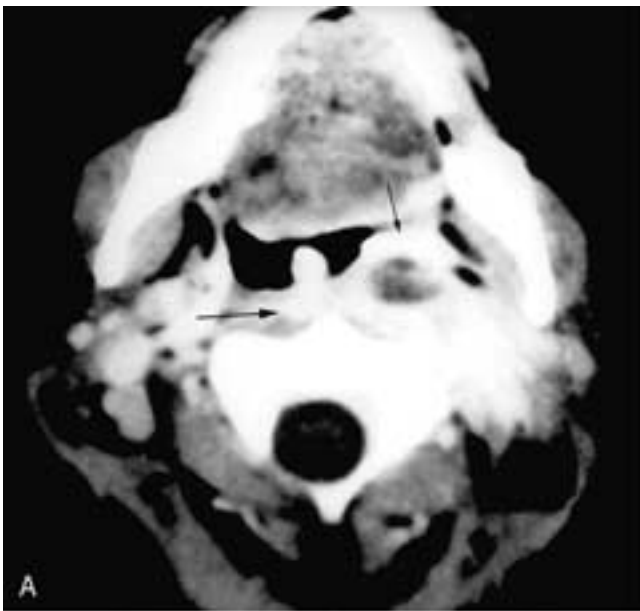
Axial contrast-enhanced CT scan (A) shows a necrotic left retropharyngeal node (*small arrow*) with a thick, enhancing rim. The enhancement extends to fill almost the entire retropharyngeal space (*large arrow*) and extends beyond the space into the left posterior neck. This was an abscessed node with a retropharyngeal abscess. Axial T1-weighted MR images (B) of another patient. There is a localized area of high signal intensity that is an abscessed left retropharyngeal node (*arrow*). Note that the remainder of the retropharyngeal space is not involved. In a third patient (C), there is a left abscessed retropharyngeal node; however, the remainder of the retropharyngeal space is also affected by an abscess. It is this latter extension that differentiates a retropharyngeal abscess with an abscessed node (C) from an abscessed retropharyngeal node alone (B).
